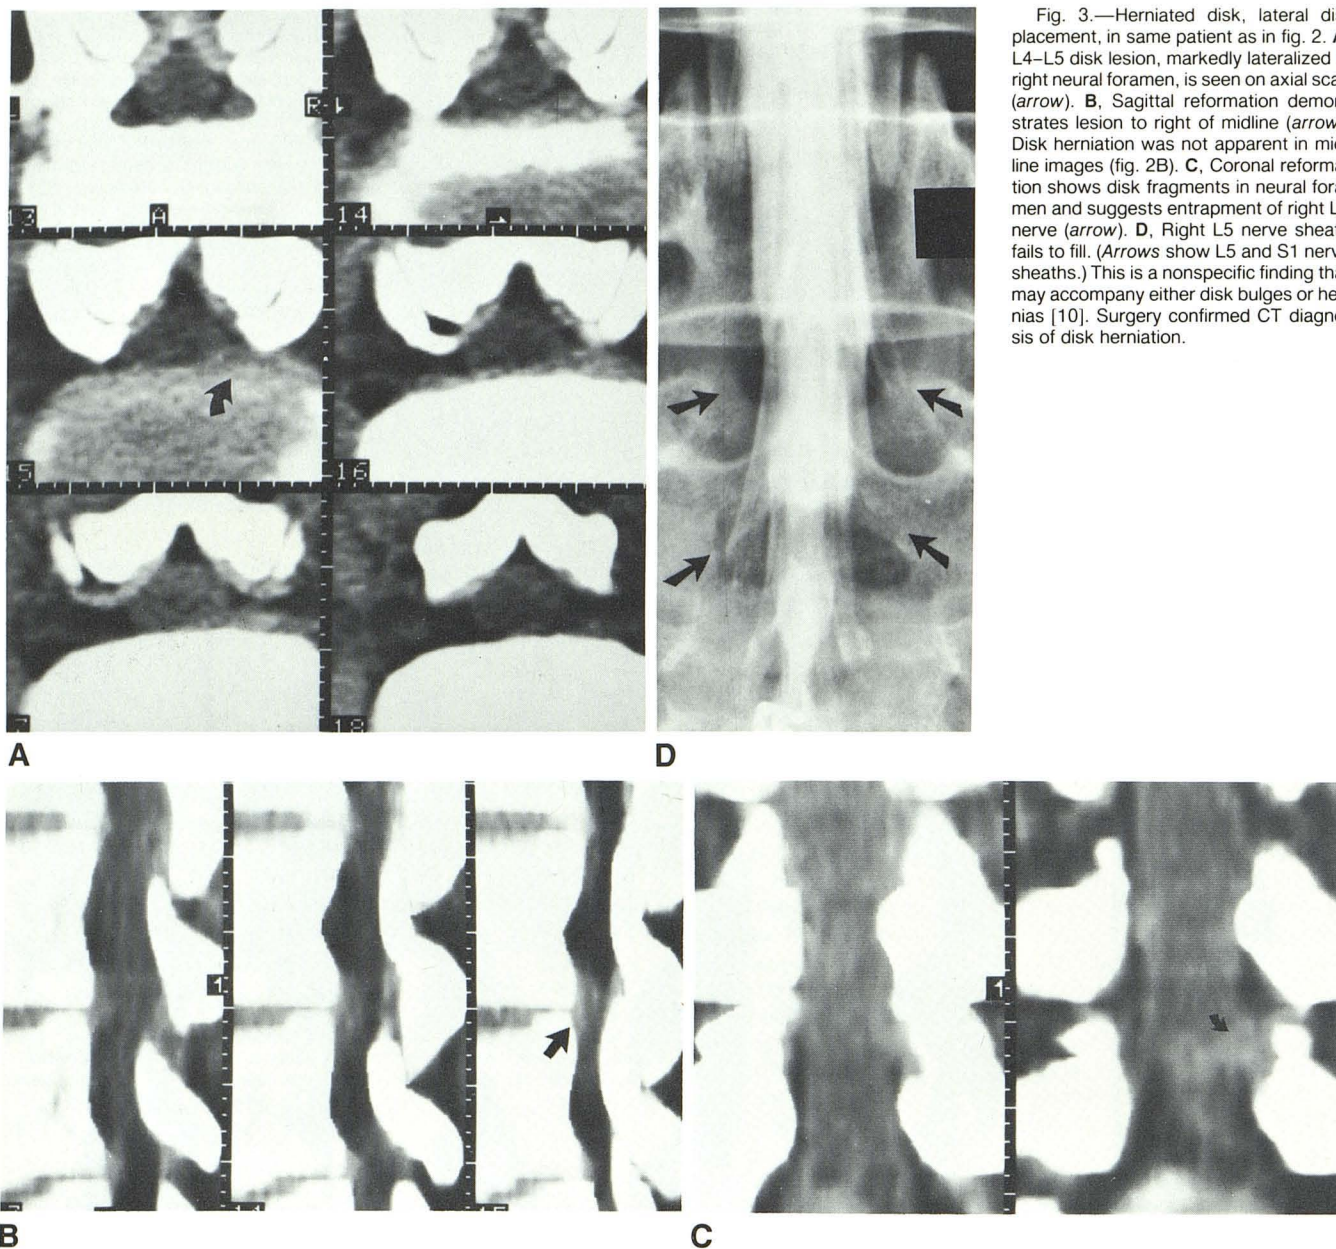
Herniated disk, lateral displacement, in same patient as in fig. 2. A, L4–L5 disk lesion, markedly lateralized in right neural foramen, is seen on axial scan (arrow). B, Sagittal reformation demonstrates lesion to right of midline (arrow). Disk herniation was not apparent in midline images (fig. 2B). C, Coronal reformation shows disk fragments in neural foramen and suggests entrapment of right L5 nerve (arrow). D, Right L5 nerve sheath fails to fill. (Arrows show L5 and S1 nerve sheaths.) This is a nonspecific finding that may accompany either disk bulges or hernias [10]. Surgery confirmed CT diagnosis of disk herniation.
